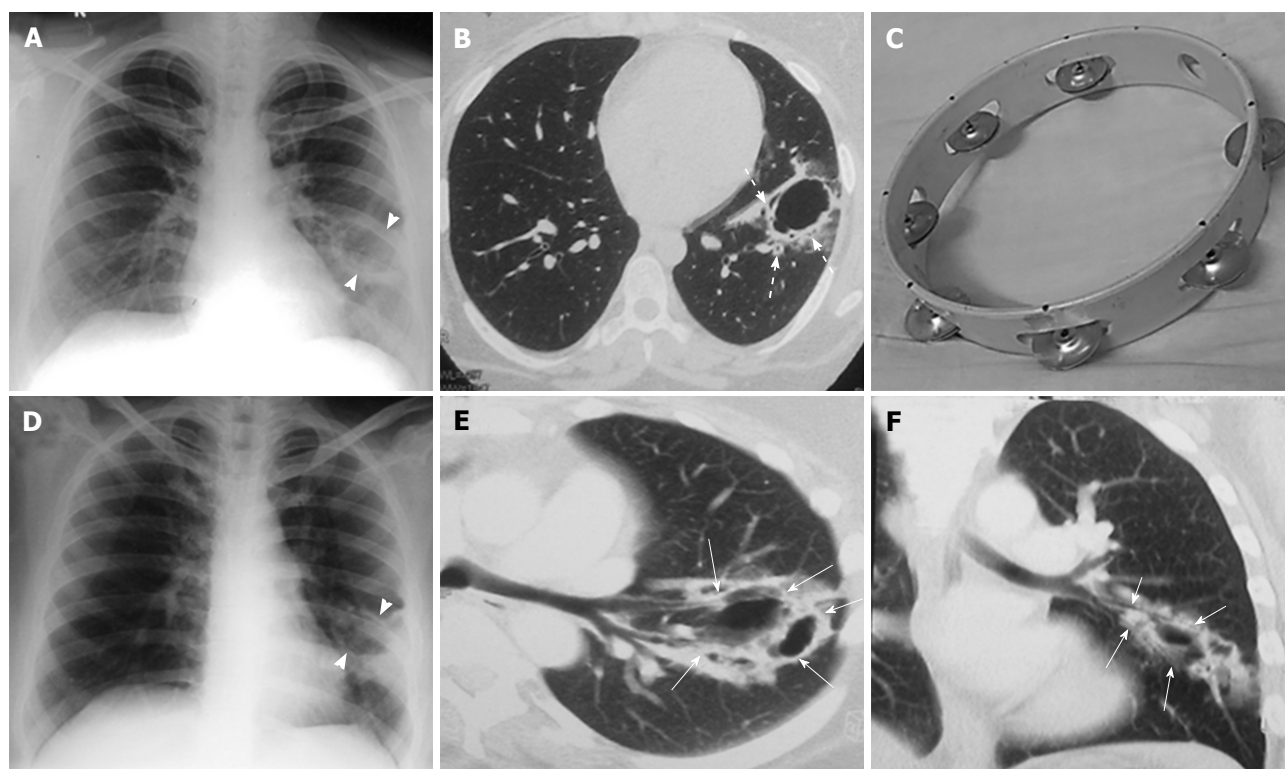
Initial and two year follow-up computed tomography imaging. Chest radiograph (A) and CT (B) in 2008 (first study) show well-defined thin-walled (4 mm) irregular cavitory lesion (arrow head) in superior segment of left lower lobe. Thick walled bronchioles (dotted arrows) are seen near the edge and within the wall of cavity with adjacent ground glass giving rise to "Tambourine" sign; (C) depicts the musical instrument "tambourine" for comparison; subsequent radiograph (D) and CT (E and F) in 2010 shows increase in size and wall thickness of the cavity. Note the adjacent bronchioles (thin white arrows) entering into the cavity wall. CT: Computed tomography.
